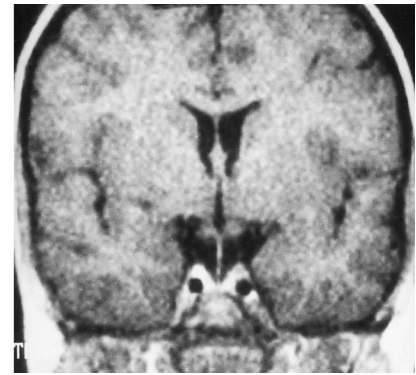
6-year-old boy with IGHD. Coronal unenhanced T1-weighted image (400/20/3) shows a thin but complete stalk, also characteristic of IGHD.
